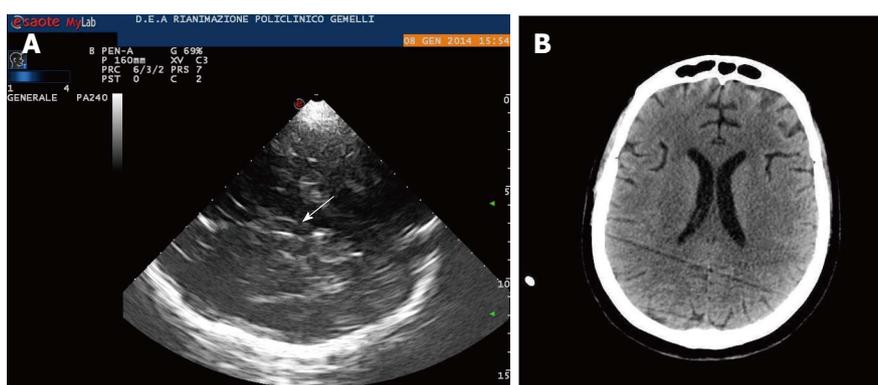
Lateral ventricles. A: Lateral ventricles in echography. Frontal horns of lateral ventricles are visualized as hypoechoic structure, well visible between two parallel lines corresponding to the medial and lateral layer of the ependima. The three parallel lines correspond to lateral layers of ependima and septum pellucidum. The image is generated by a sectorial probe, and lateral ventricle ipsilateral to the probe is depicted at the same depth of the third ventricle. Arrow shows third ventricle, Small arrow heads on the left show frontal horns of lateral ventricles; B: Lateral ventricles in computed tomography (CT). CT scan of lateral ventricles correspondent of Figure 4A is shown.
